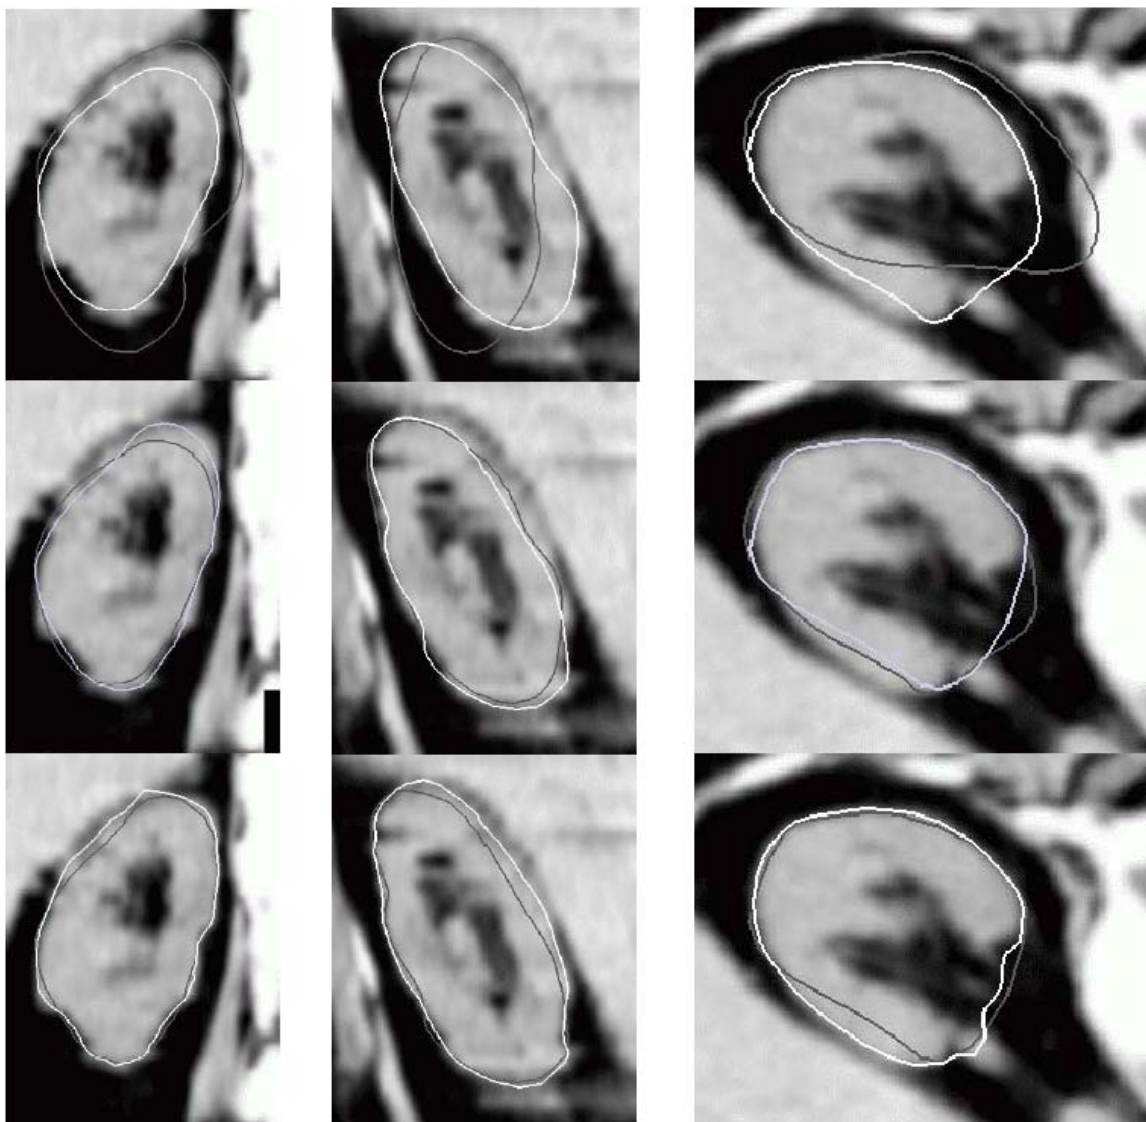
Segmentation, step-by-step: Initial Hand Placement (black contour), Final Segmentation (white contour)- all rows, from left to right, results on Coronal, Sagittal and Axial CT slices. The overlaid contours compare progress through two consecutive stages of deformation. Top row: The two stages are the initial position of the kidney model vs. the figural similarity transform and transform via PGA. Middle: Similarity transform + PGA vs. medial atom transformations. Bottom: medial atom transformations vs. 3D boundary displacements (This step was not used in the study). (Courtesy Pizer et al 2002)
